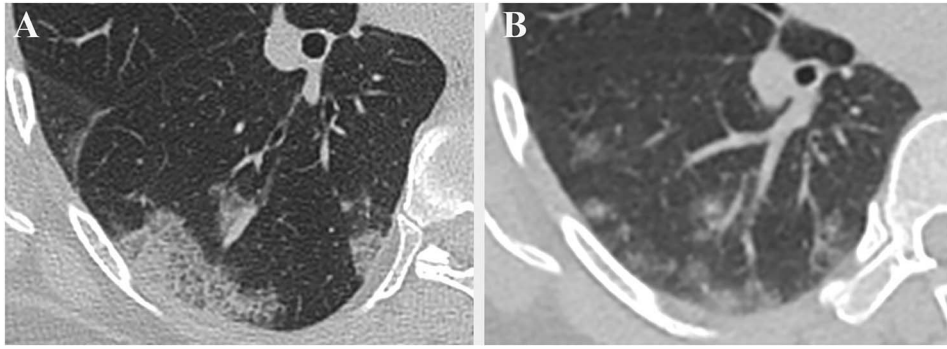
Remission of the lung lesions of a 49-year-old female 2019-nCoV patient. (A) The initial HRCT showed typical “crazy-paving” signs at the right lower lobe. (B) The density and extent of the airspace opacification prominently reduced at the follow-up CT.
